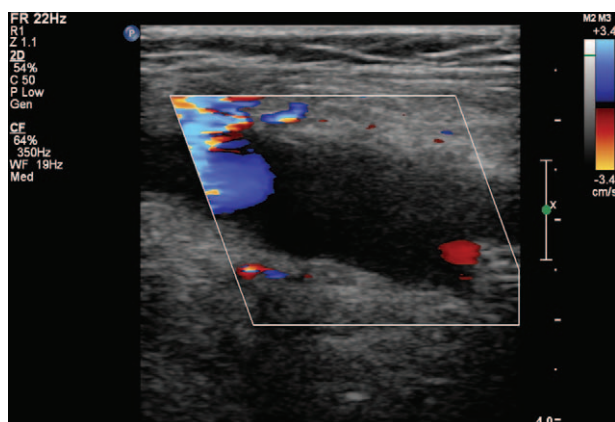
CDFI showing no obvious blood flow signal in the mass. CDFI = color Doppler flow imaging.
